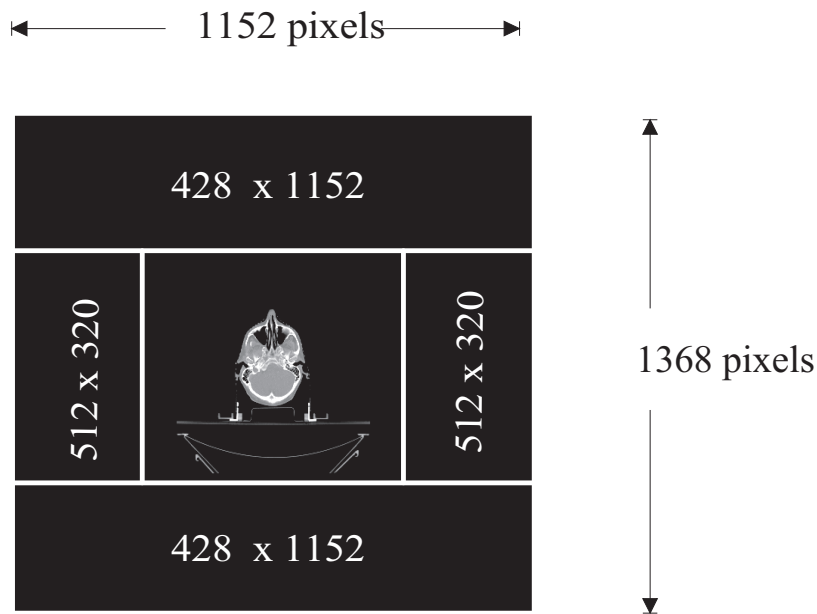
A modified CT slice consisting of the original 512×512 matrix surrounded by two pairs of matrices of dimensions 428×1152 and 512×320 .
